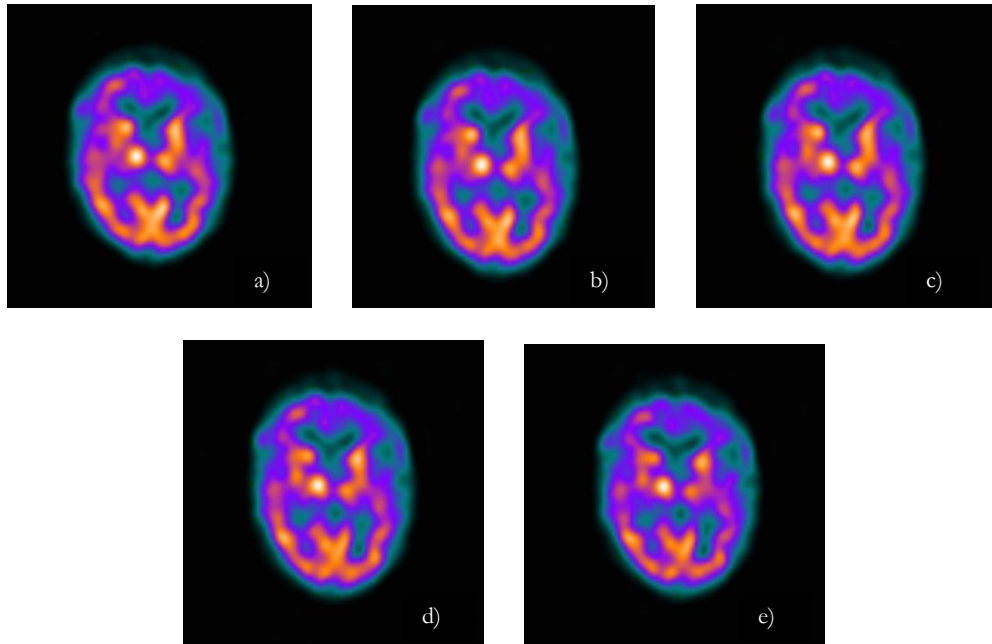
Transaxial section of the brain in a rCBF SPECT image corresponding to an activity level of a) 1000 MBq, b) 875 MBq, c) 750 MBq, d) 625 MBq and e) 500 MBq.
